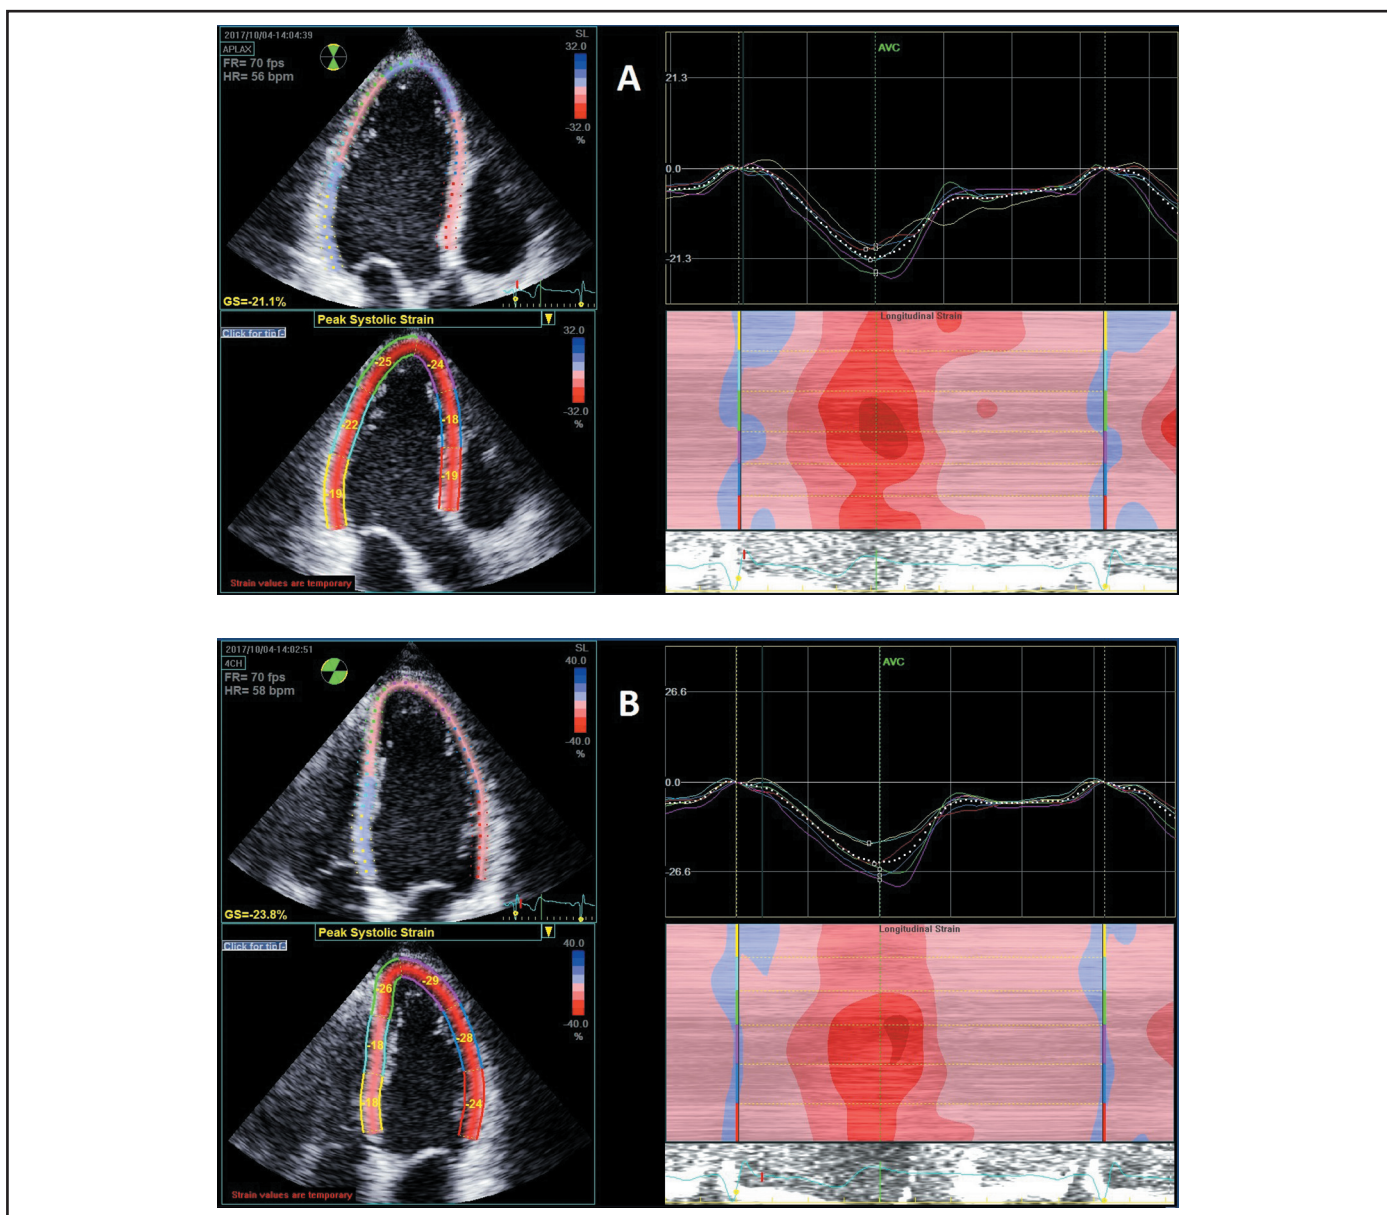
Apical 4 (A), apical 3 (B) and apical 2.
